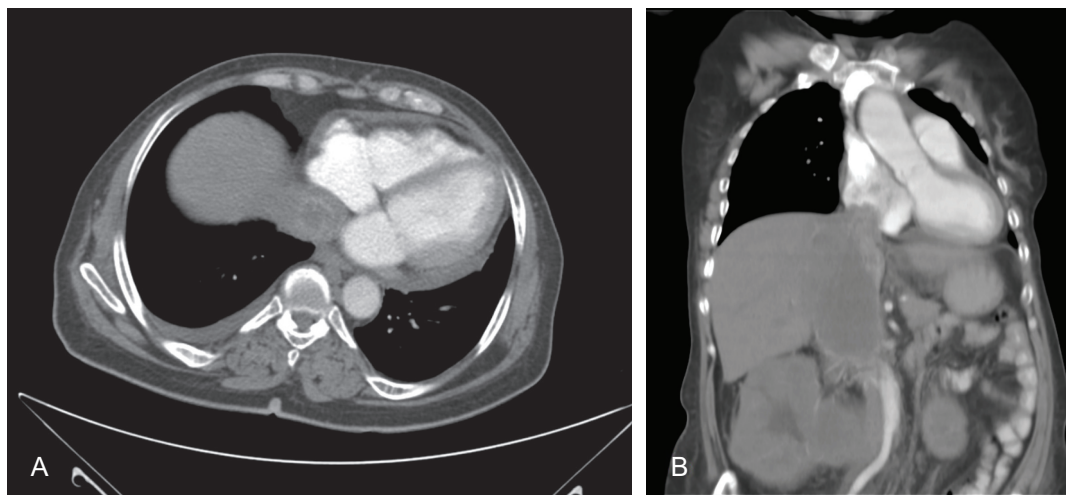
Contrast-enhanced computed tomography (CT) scan axial view at the level of lower chest/upper abdomen arterial phase (A) showing dilated inferior vena cava at the level of inferior cavoatrial junction along with intraluminal heterogeneous mainly hyperattenuating rounded structure in keeping with thrombus; coronal view chest and abdomen CT scan venous phase (B) showing dilated right atrium with evidence of intra-atrial filling defect.
